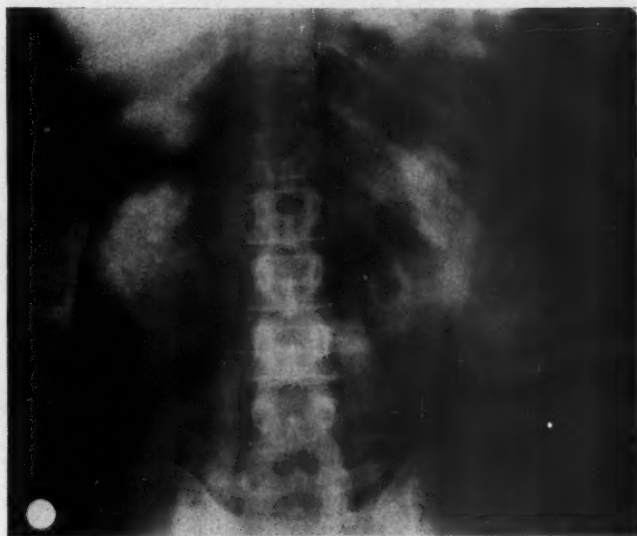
Air injection x-ray of Fig. 6 showing air around the right kidney, in a crescent horn around a mass (adrenal) above the kidney. Such shadow occurred with carcinoma of the adrenal.
